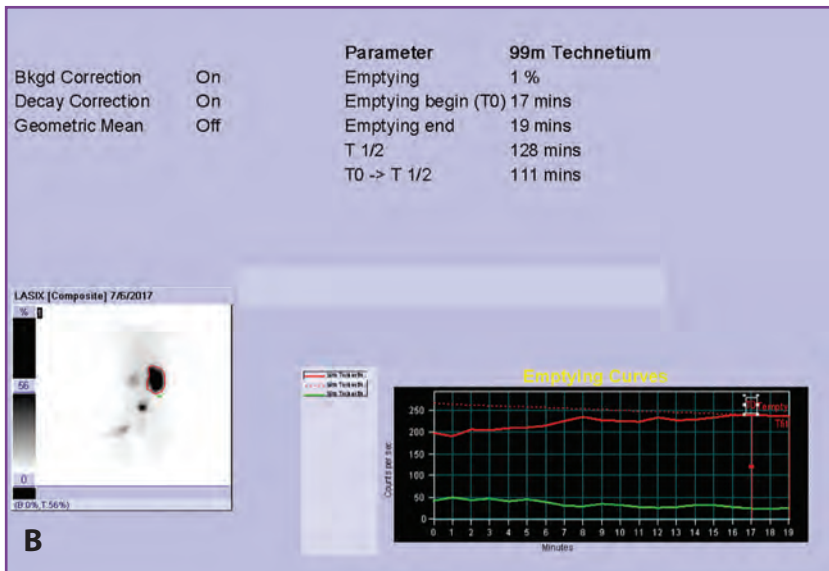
Renal scintigraphy. A, Ultrasonographic image shows a right kidney with dilation of the renal pelvis and calyces. B, Renal scintigraphy (images are posterior) demonstrates a dilated right kidney with retention of tracer when compared to the left kidney.
